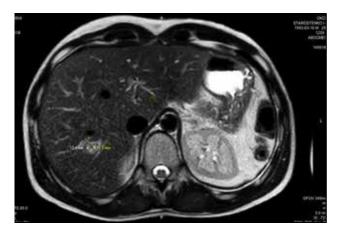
MRI of the abdominal organs 3 months after the corporoduodenal resection of the pancreas and atypical liver resection with signs of the disease progression in the liver S7 segment
